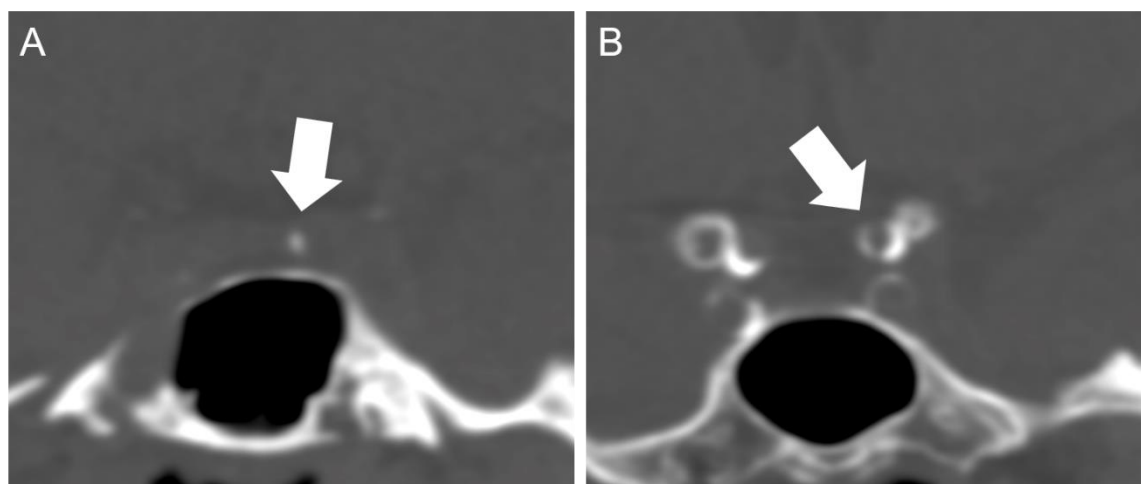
Intracranial arterial calcification (IAC) pattern on computed tomography (CT). Intimal IAC (A) as a patchy cluster and medial IAC (B) extending up to the whole circumference of vessel wall.
